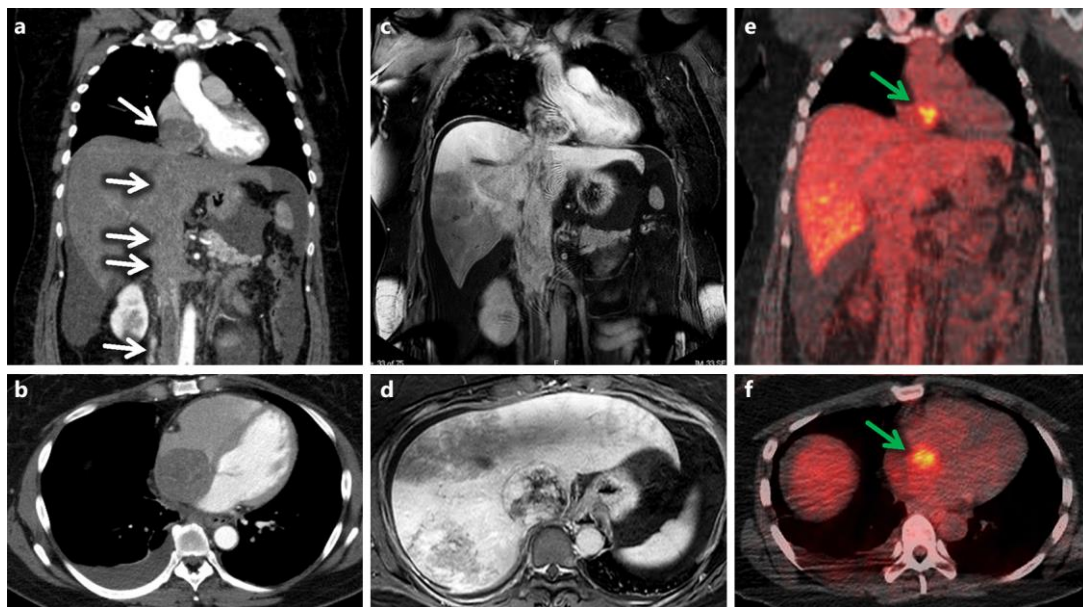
Clinical images. a, b Coronal (a) and transverse (b) sections of computed tomography (CT) images. A tumor is visible in the right atrium that is continuously present within the inferior vena cava (arrows). c, d Coronal (c) and transverse (d) sections of magnetic resonance images. e, f Coronal (e) and transverse (f) sections of PET/CT-merged images. Increased FDG uptake may be observed in the right atrium (arrows).
